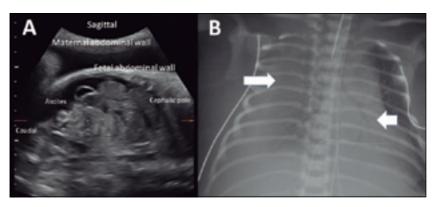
A: Sagittal view of an obstetric ultrasound taken at admission showing fetal ascites. Anatomical landmarks are indicated. B: Neonatal chest x-ray showing right pleural effusion with left lung compression (long arrow) and consolidation with air bronchogram at right (pneumonia alba; short arrow).
